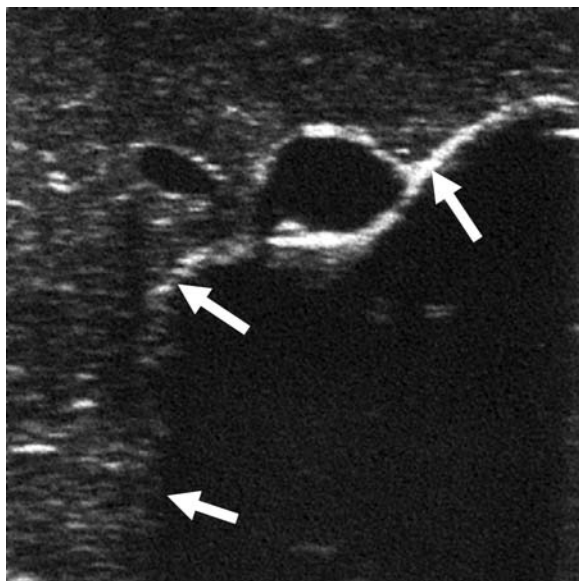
Ice ball forming during cryoablation is visible under ultrasound imaging (arrows). (From Ref. 14.)
